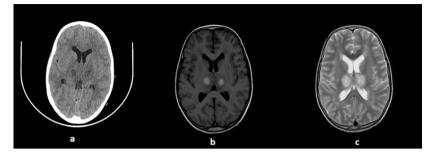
Axial CT (a), T1W MRI (b), T2W MRI (c) images of brain
